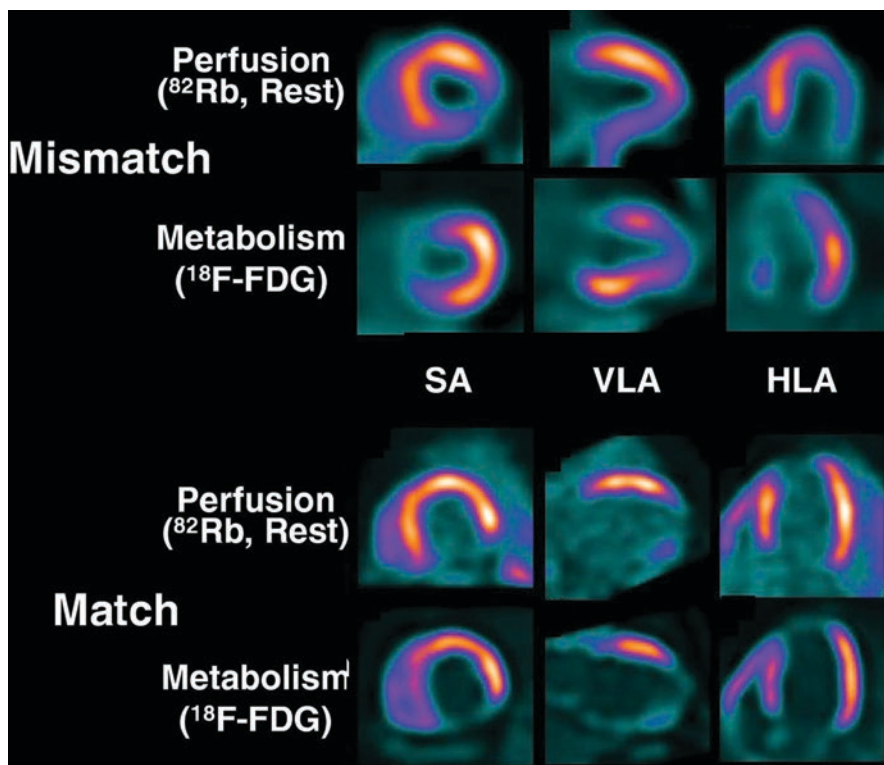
Assessment of myocardial viability by FDG PET: Examples of perfusion–metabolism mismatch patterns. (Reprinted with permission from Bengel FM, Higuchi T, Javadi MS, Lautamäki R. *J Am Coll Cardiol.* 2009 Jun 30;54(1):1–15. <https://doi.org/10.1016/j.jacc.2009.02.065>. Review)
